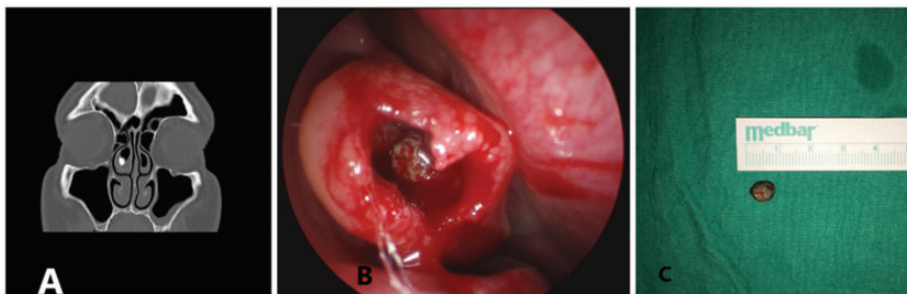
(a) Paranasal computed tomographic scan showing a rhinolith within the right concha bullosa before surgery. (b) A rhinolith in the concha bullosa was observed in nasal endoscopy during the surgery. (c) Gross appearance of the extracted rhinolith.
